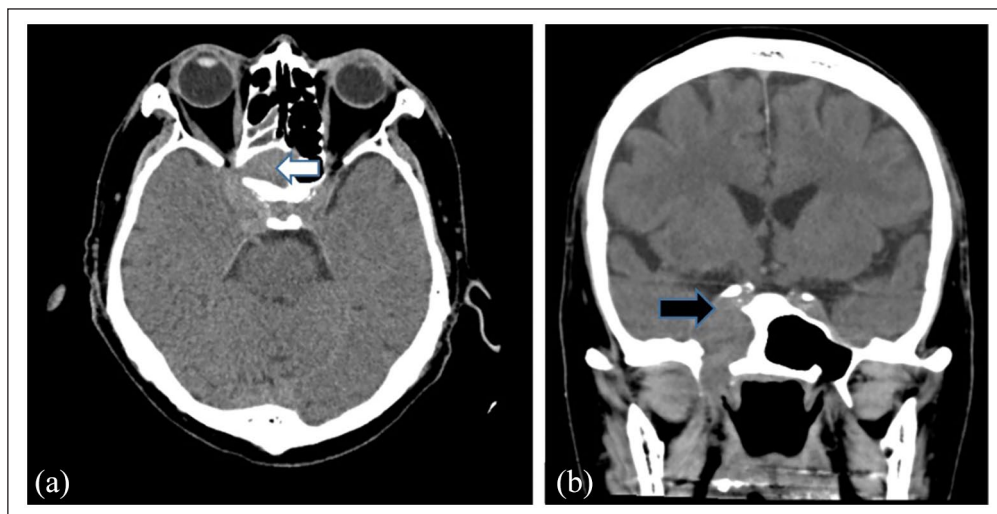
(a) Axial slice CT paranasal sinus at the level of sphenoid sinus with white arrow showing contrast-enhanced lesion within the right sphenoid sinus with involvement of cavernous sinus. (b) Note the bony dehiscence on coronal slice at the superior sphenoid wall, pointed out with black arrow.
